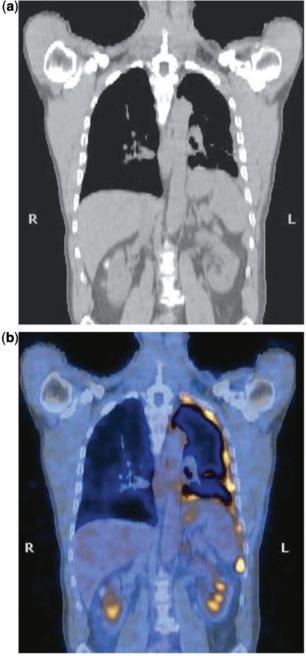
A 47-year-old man with lung cancer. (a, c) CT reveals nodularity and thickening of the pleura. (b, d) Note increased uptake indicating malignancy on the PET/CT views.
